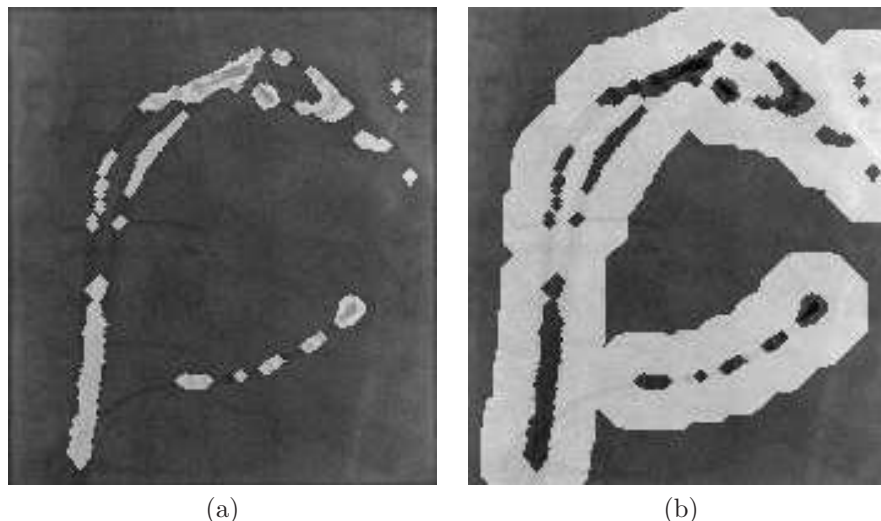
(a) Image output of the FV filter followed by morphological opening, $I_{1,1}$, overlaid with the corresponding X-ray image for Case 2. (b) Image output, $I_{3,1}$, overlaid with the corresponding X-ray image for Case 2.
